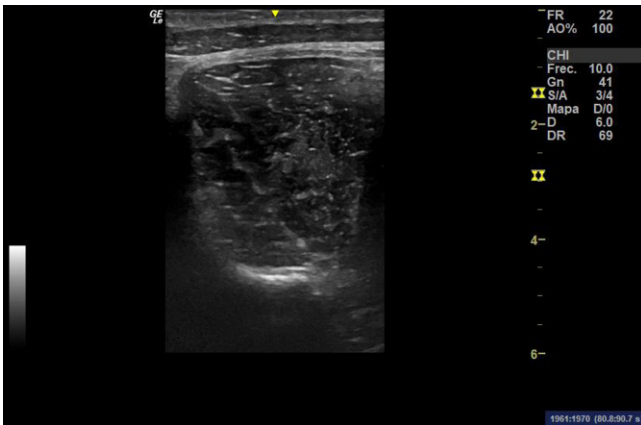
◀ LMult ultrasound image. LMult Lumbar Multifidus
